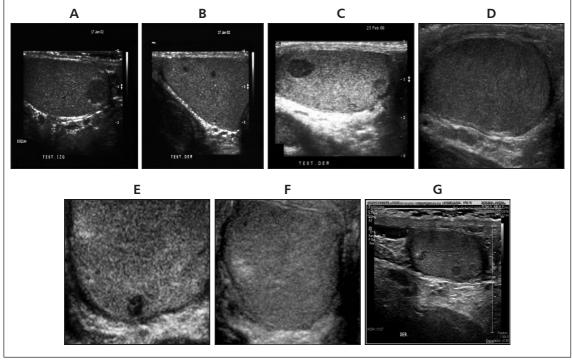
Evolution of testicular ultrasonography. Left (A) and right (B) testicular ultrasound prior to tumorectomy in 2003. Right testicle ultrasound in 2006 prior to tumorectomy (C). Right testicle nodule disappearance with testosterone replacement on 2009 (D). Right testicle nodule relapse after one year without testosterone in 2010 (E). Right testicle without nodules while on testosterone replacement in 2012 (F). Right testicle nodule relapse after two years without testosterone in 2016 (G).
